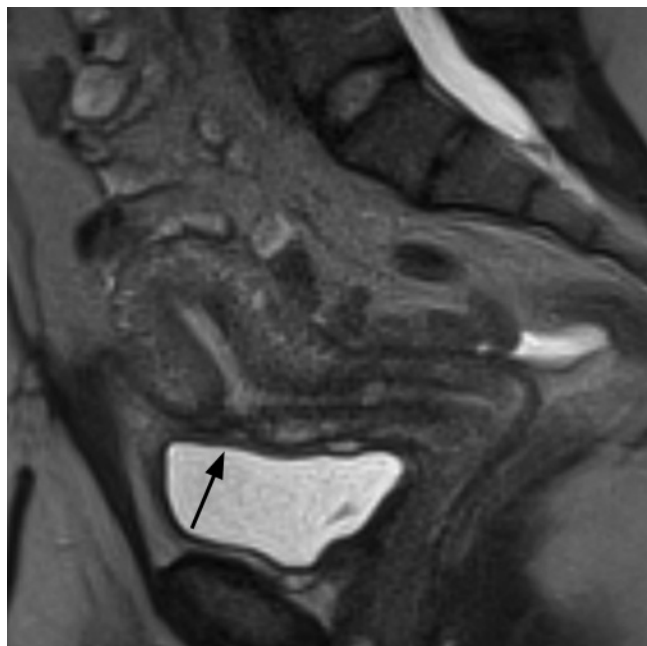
Cesarean scar defect. Sagittal T2-weighted SS-ETSE image demonstrates a prominent scar with marked myometrial thinning in the anterior lower uterine segment, at site of prior caesarean section (arrow).
